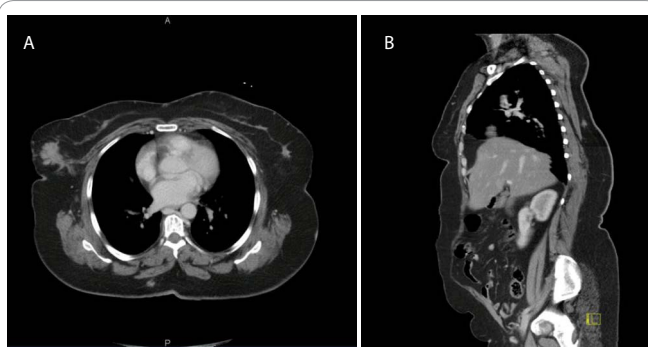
CT-CAP. Coronal 8b: Sagittal Views showing the subcutaneous metastatic nodules
